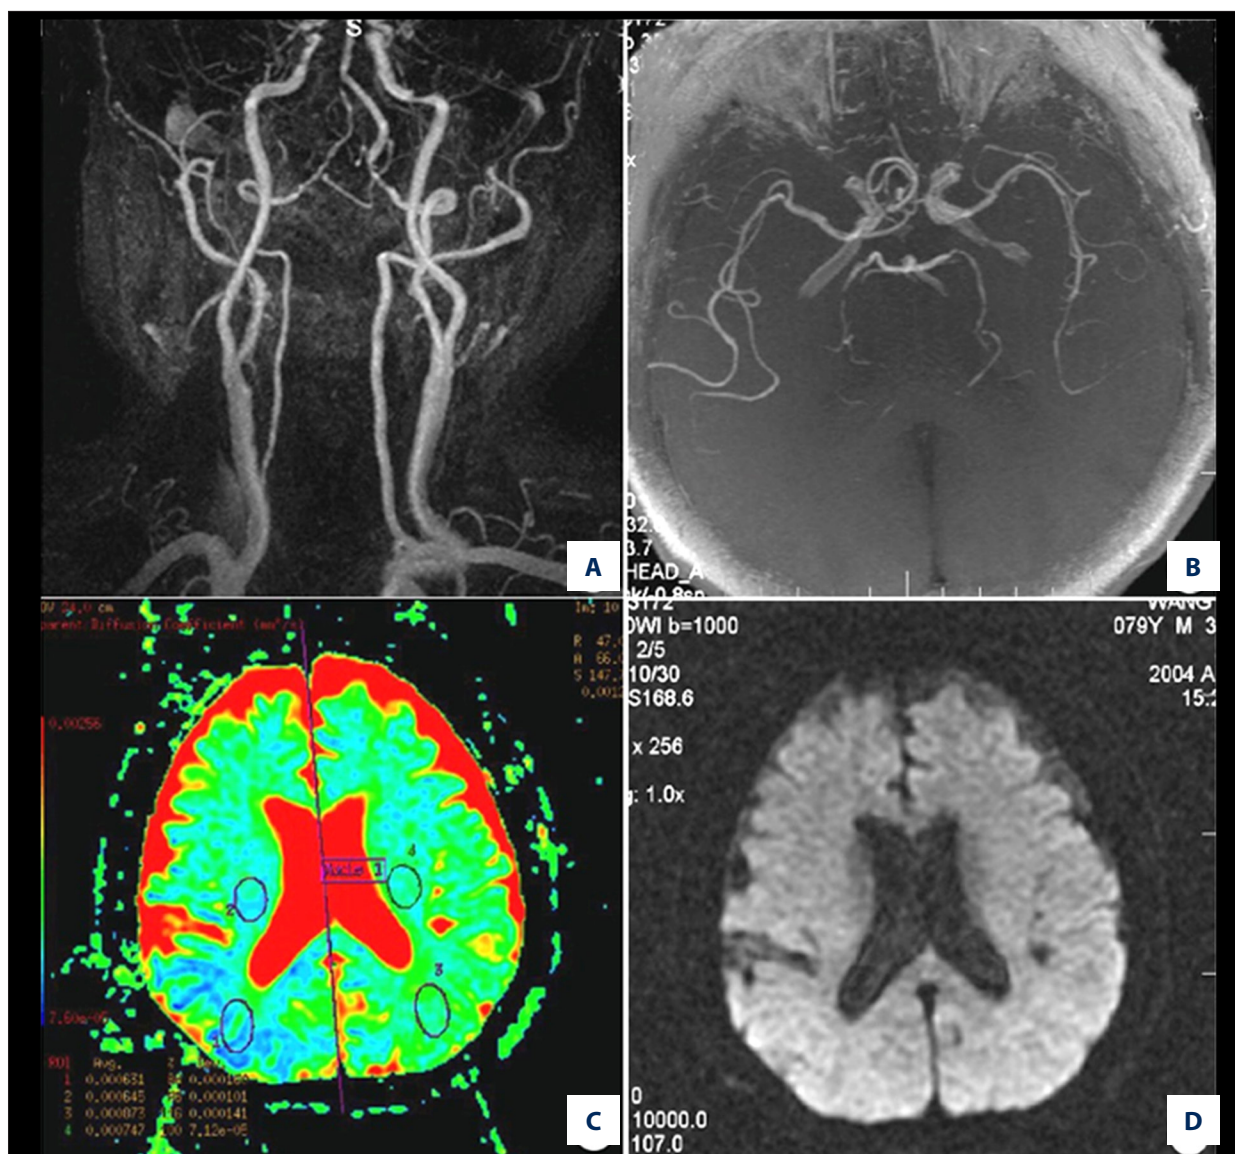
(A) A 79-year-old man had from paroxysm dizziness, aphasia, and numbness of the left leg several times. (A, B). MRA showed there were multiple plaques in the bulb of the right CCA, left ICA, and the distal end of left VA. The walls were irregular (arrow), and the bilateral PCA were very dark. (C) ADC images showed there was large ischemic area in the right temporal and occipital lobe (arrow). (D) No abnormality was found on DWI image.
